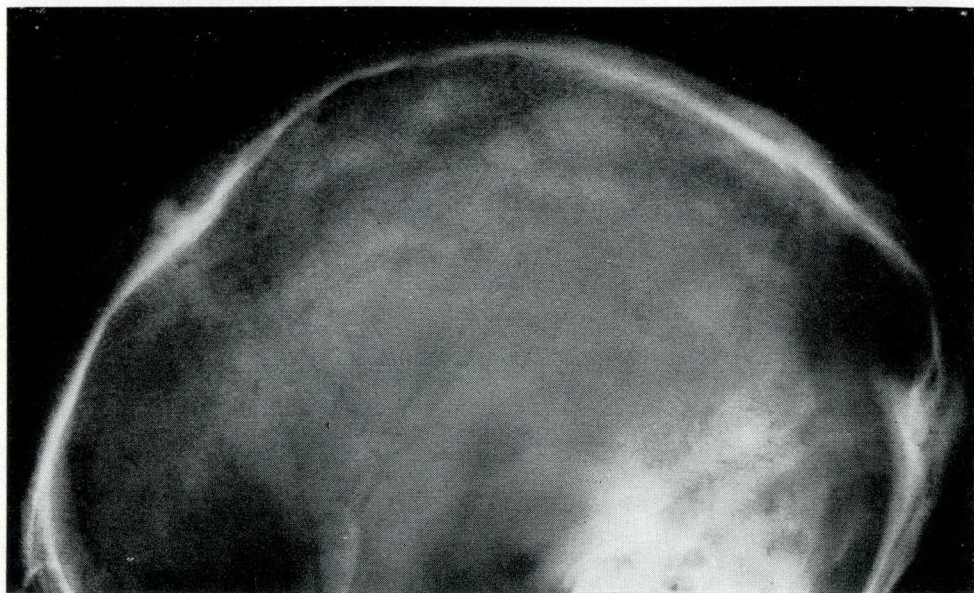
Radiograph of skull showing osteomata of outer table.
